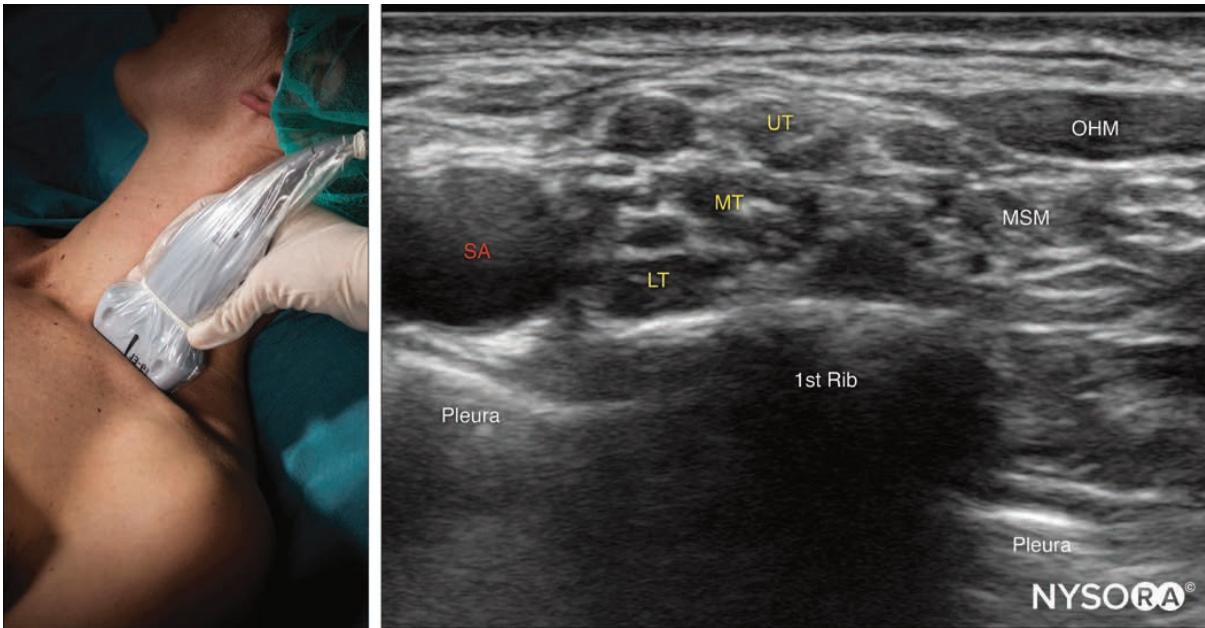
Transducer position and ultrasound image to perform a supraclavicular block. SA, subclavian artery; LT, lower trunk; MT, middle trunk; UT, upper trunk; MSM, middle scalene muscle; OHM, omohyoid muscle.
